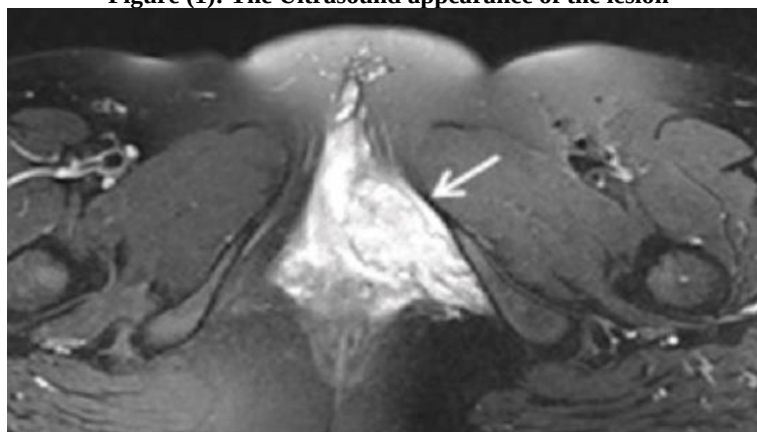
MRI appearance of the lesion
